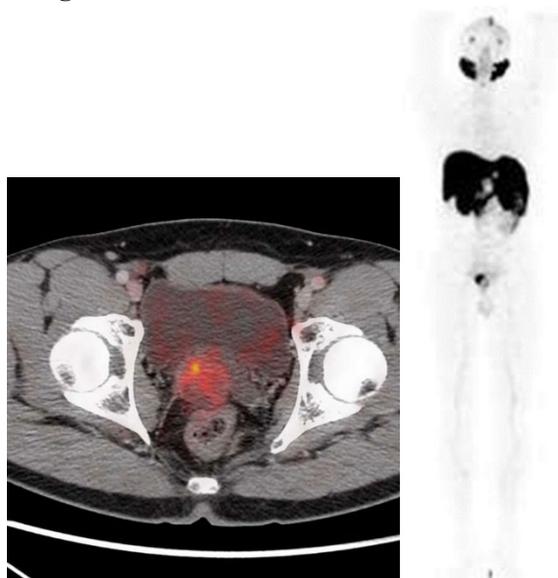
(A) axial & coronal MIP (B) image shows synovial sarcoma prostate. Fused PET/CT images shows PSMA avid lesion with areas of necrosis within involving prostate. No distant metastases seen.
